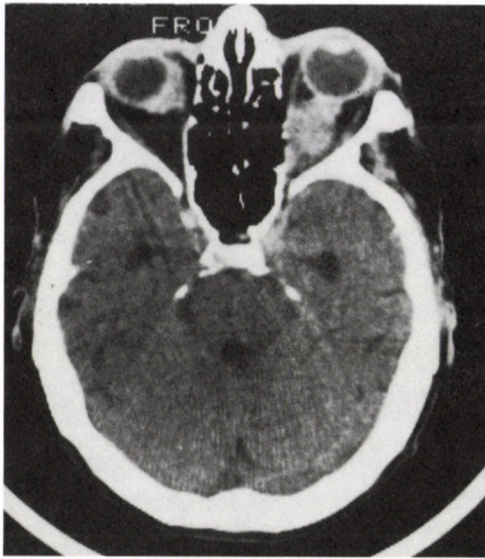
CT scan demonstrates bilateral orbital involvement caused by non-Hodgkin lymphoma. On the right side the tumour is engulfing the optical nerve, on the left there is an infiltration lying medially to the globe
